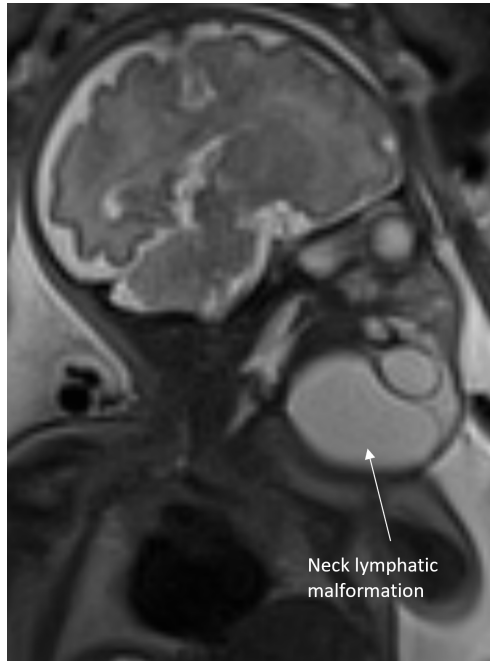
T2 HASTE Coronal MRI image of 25 week fetus with anterior neck lymphatic malformation
